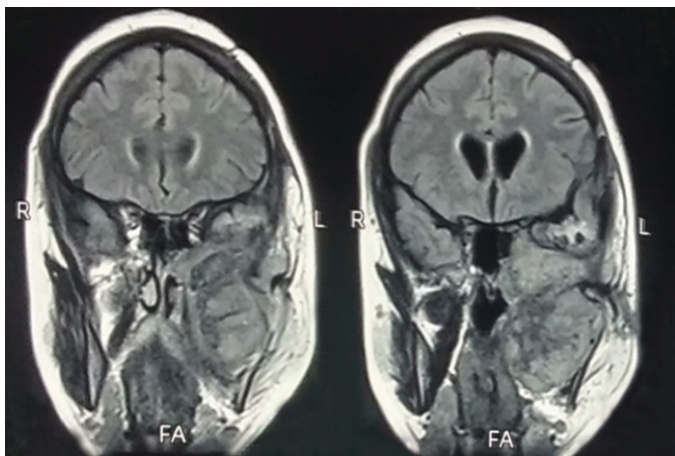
T1 Weighted MRI Coronal section showing tumor extension up to oral cavity
